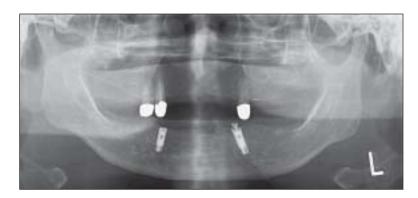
Panoramic radiograph obtained 2 weeks after immediate implant placement. A perimandibular abscess had developed in the left mandible.
